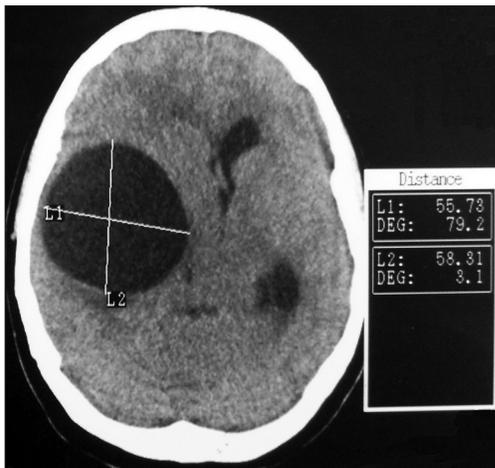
CT scan brain plain showing large cystic lesion in right temporoparietal region causing effacement of the ventricle and midline shift
